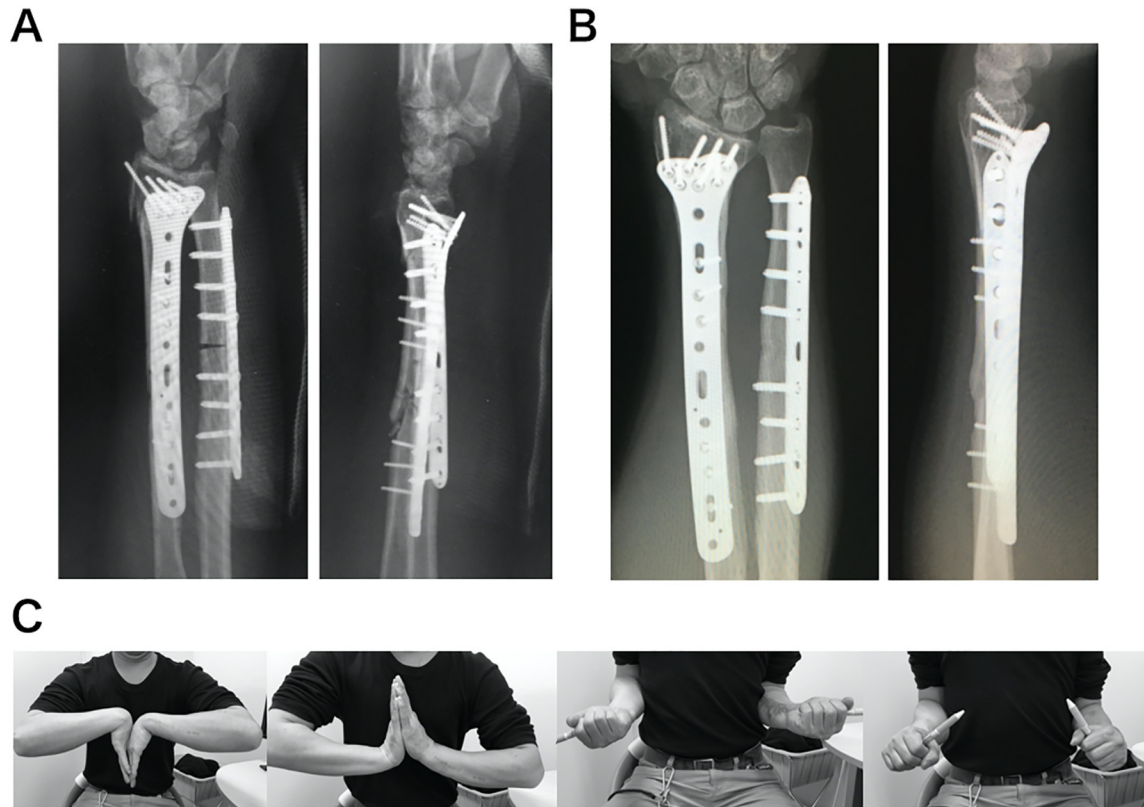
A) The postoperative radiography shows that correction of alignment has been achieved.
